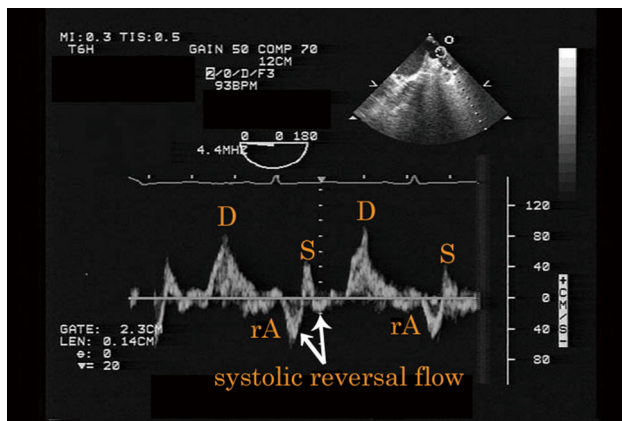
Pattern of pulmonary venous flow in the left upper pulmonary vein on pulsed-wave Doppler imaging during sinus rhythm. The arrows indicate systolic (early systolic and late systolic) flow reversal. S systolic wave (S wave), D diastolic wave (D wave), rA atrial reversal
